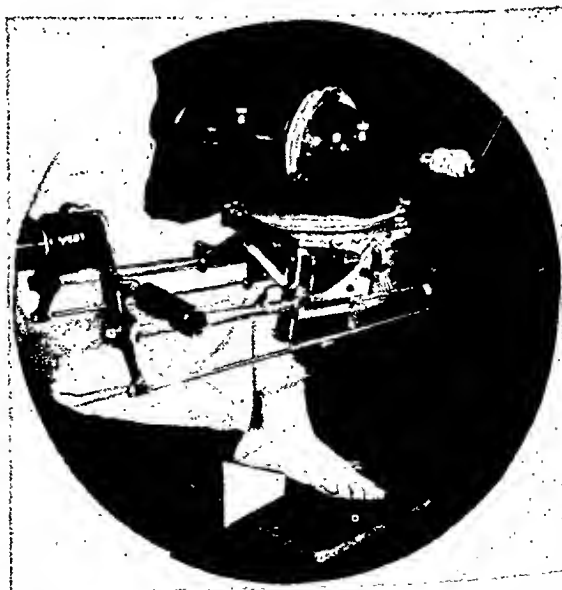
Roentgenogram showing foot inverted, with the outside elevated to a thirty-degree angle with the film holder.
